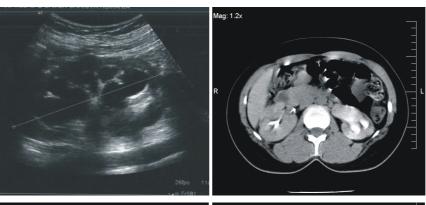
CT scan using contrast substance of the left kidney showing reduced and delayed secretion and excretion, dilation of the renal pelvis and left lumbar ureter.
